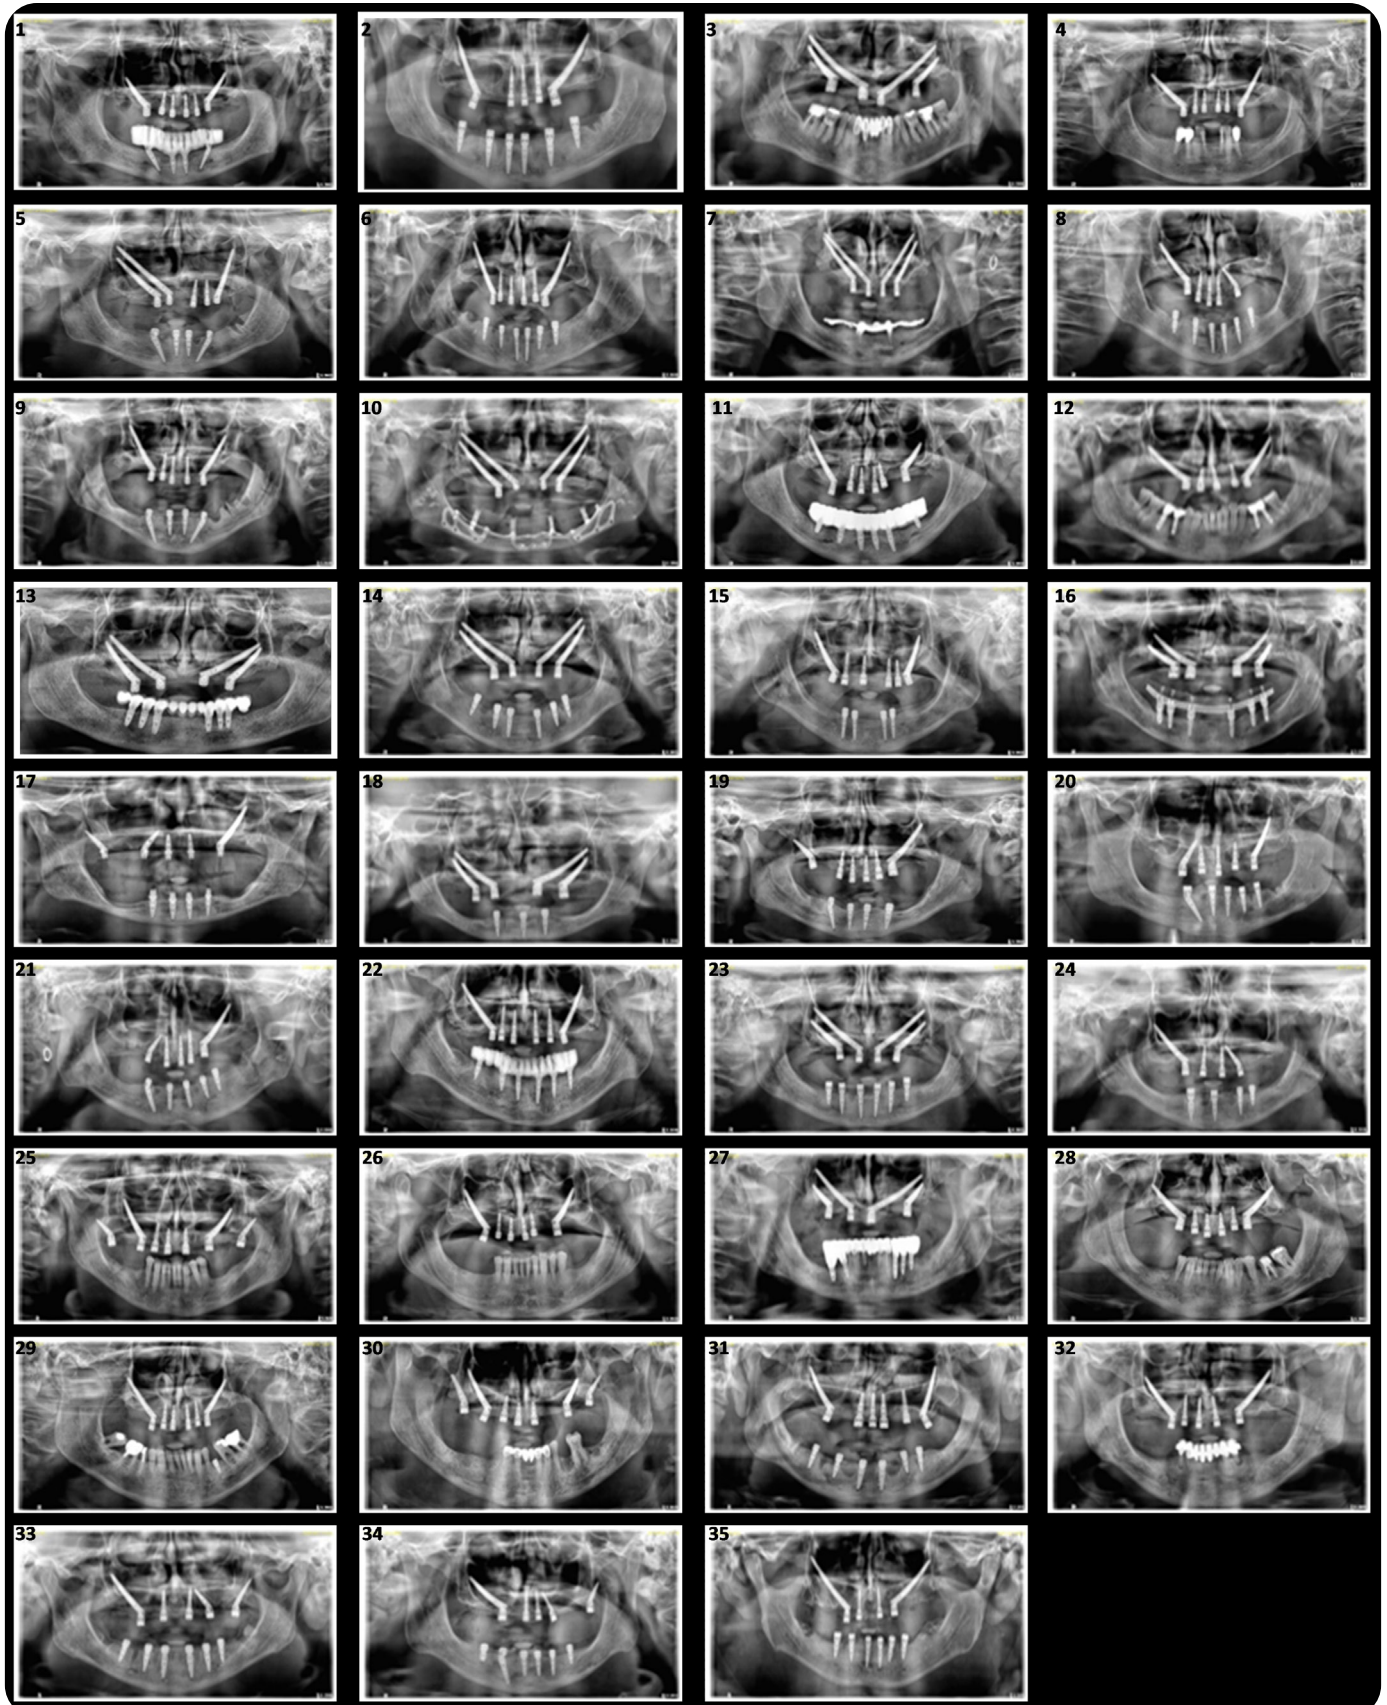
Postoperative panoramic radiographs of all patients.
